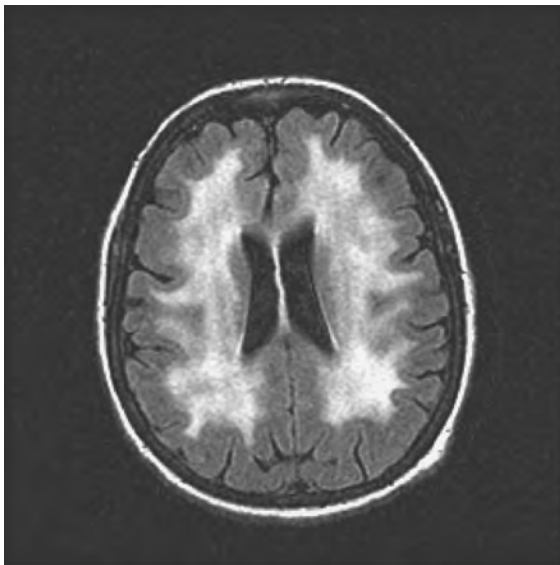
Leukoencephalopathy. Fluid-attenuated inversion recovery (FLAIR) magnetic resonance image of a patient with breast cancer treated with intrathecal methotrexate only for leptomeningeal metastasis. There is extensive white matter hyperintensity that is bilateral and symmetric. She had no cognitive impairment.
